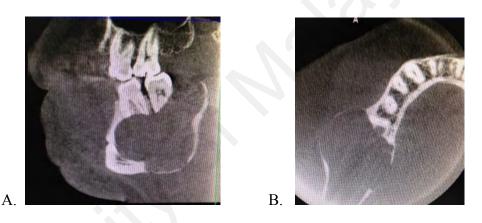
Sagittal (A) and axial (B) CT scan views of SMA at left side of mandible.
